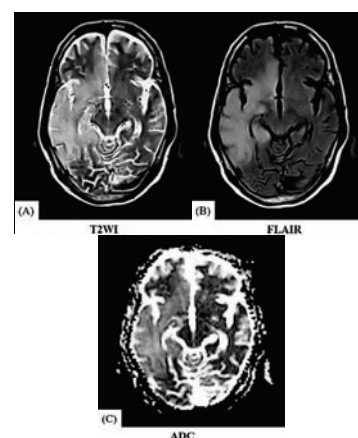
21-Year-Old Male with Dengue Encephalitis. Axial T2-Weighted Image (A) and a Axial FLAIR Image (B) Showing Hyperintensity Involving the Right Fronto-Temporal Lobe, with Areas of Restricted Diffusion Apparent Diffusion Coefficient Maps (C)
